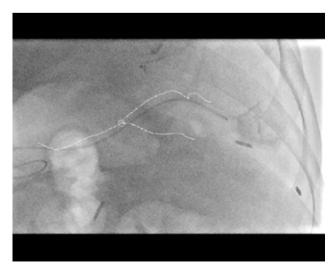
Fluoroscopic image of the point of embolization, vessel path overlaid from intra arterial CT scan
